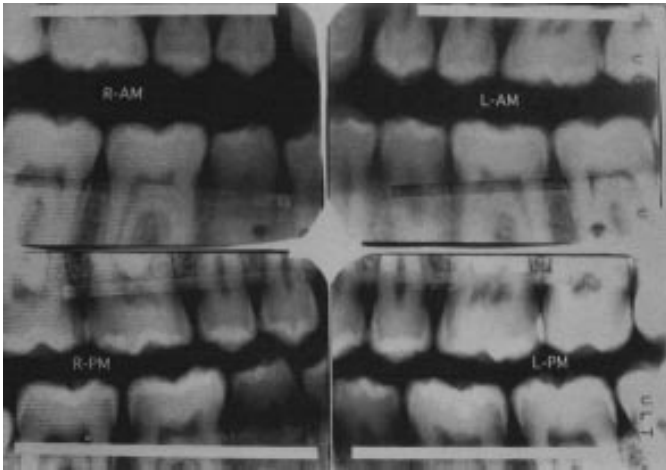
Digitized image showing a match between antemortem and postmortem radiographs. A horizontal section from the postmortem film (PM) was digitally “cut” and superimposed along the corresponding section on the antemortem film (AM). The placement of the cut image on the antemortem film was approximated using gross root morphology. A match was determined if the anatomic feature was within 0.1 mm. In this figure all vertical anatomic landmarks were perfectly aligned. This can be clearly seen when examining vertical radiolucent and radiopaque lines extending from the top of the cut section, through the cut section and again below it.
